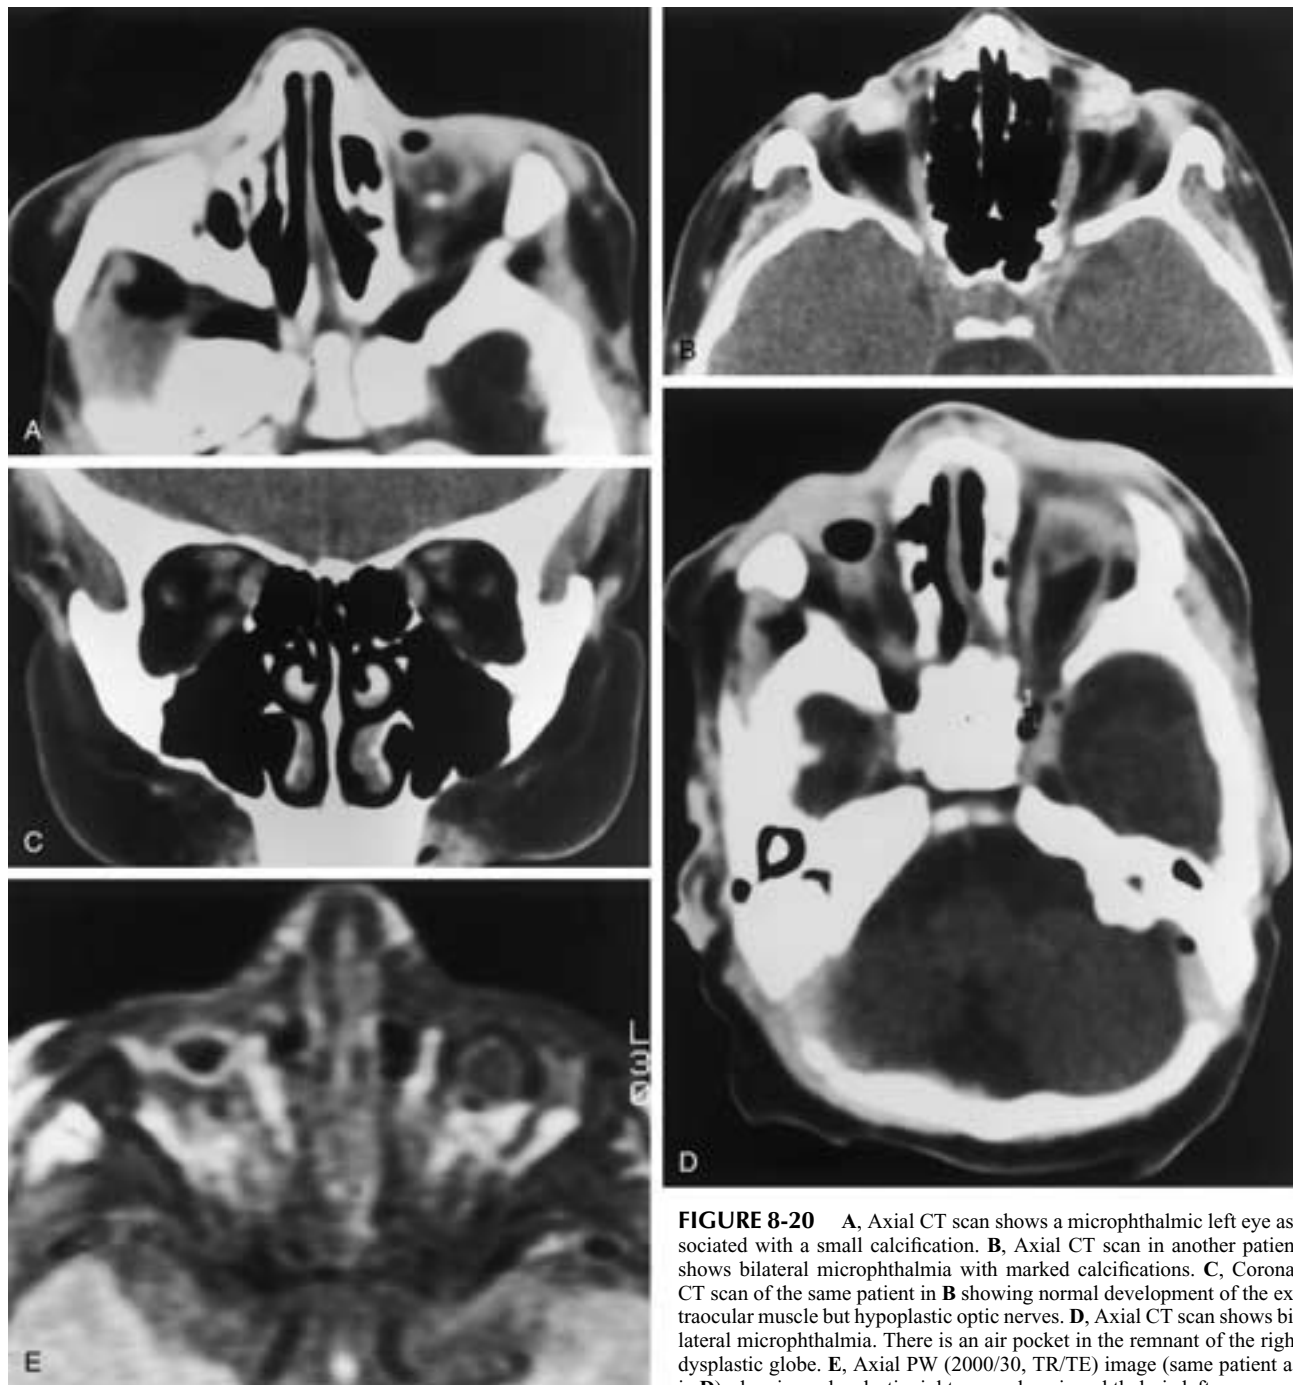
A, Axial CT scan shows a microphthalmic left eye associated with a small calcification. B, Axial CT scan in another patient shows bilateral microphthalmia with marked calcifications. C, Coronal CT scan of the same patient in B showing normal development of the extraocular muscle but hypoplastic optic nerves. D, Axial CT scan shows bilateral microphthalmia. There is an air pocket in the remnant of the right dysplastic globe. E, Axial PW (2000/30, TR/TE) image (same patient as in D), showing a dysplastic right eye and a microphthalmic left eye.
